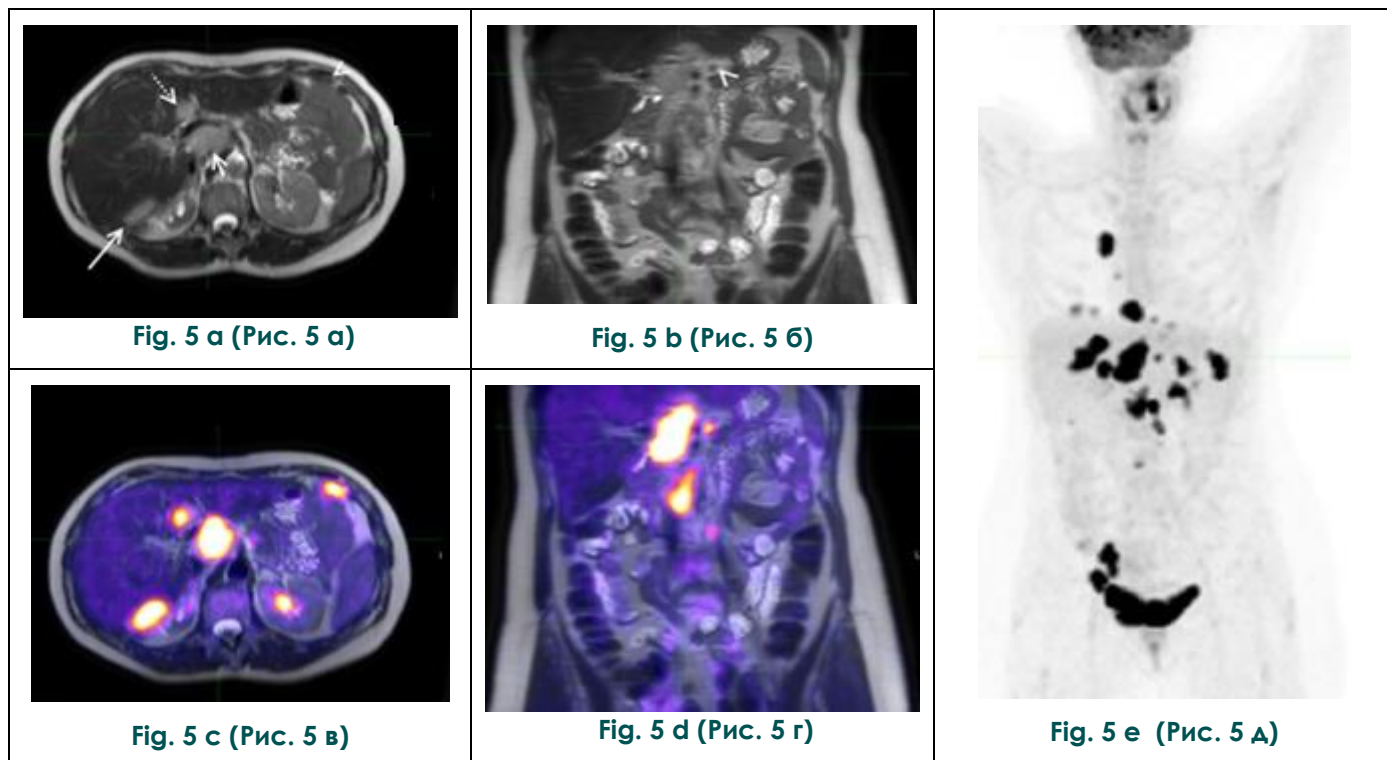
PET/MRI, in ovarian cancer.
